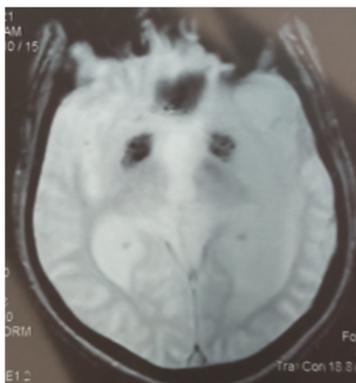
MRI brain plain, axial T2, showing neurodegeneration with brain iron accumulation.
